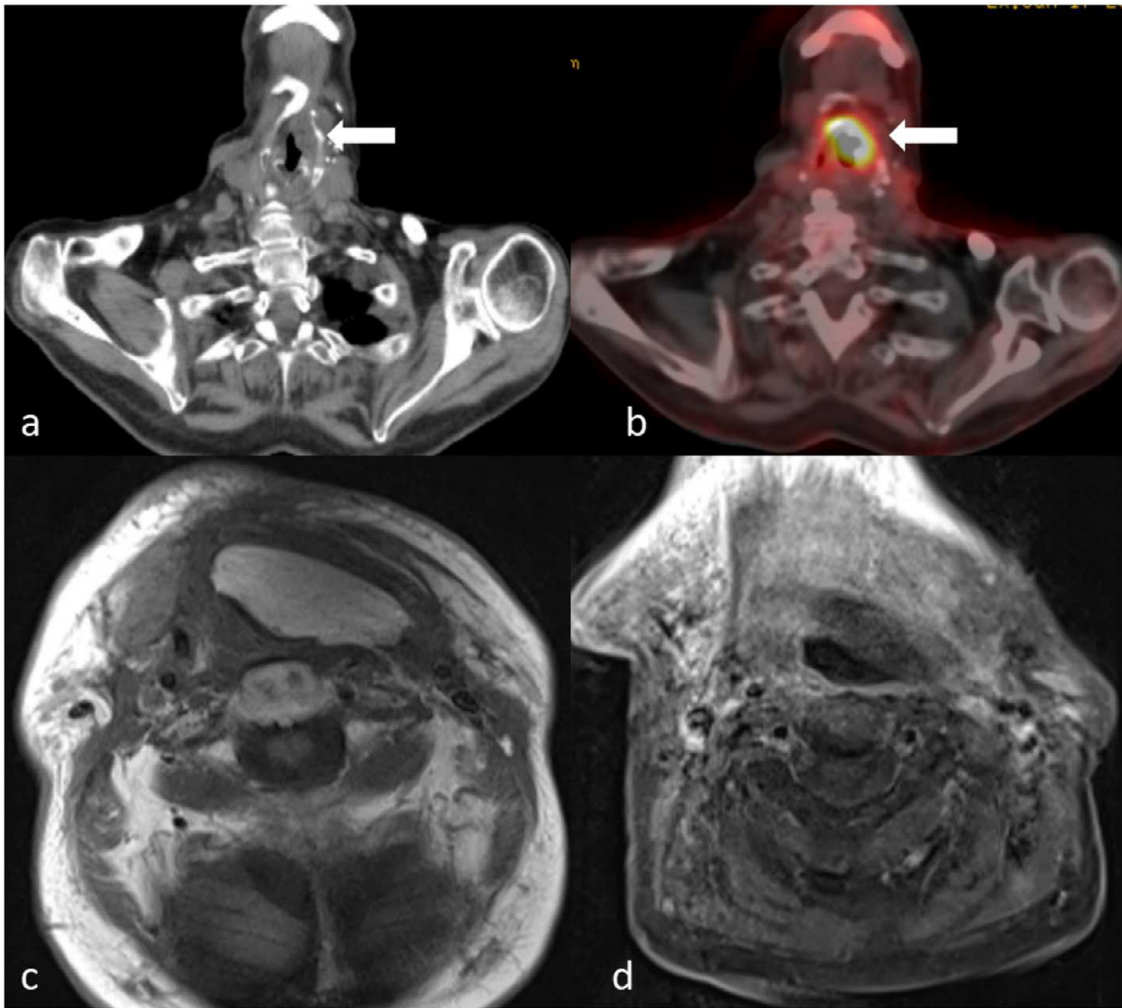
Axial PET-CT images show new recurrent laryngeal lesion (A), FDG uptake is seen (B) (white arrows). Axial non fat-sat T1W image (C) and axial fat sat T1W image (D) show post operative changes and flap reconstruction after the second operation.
